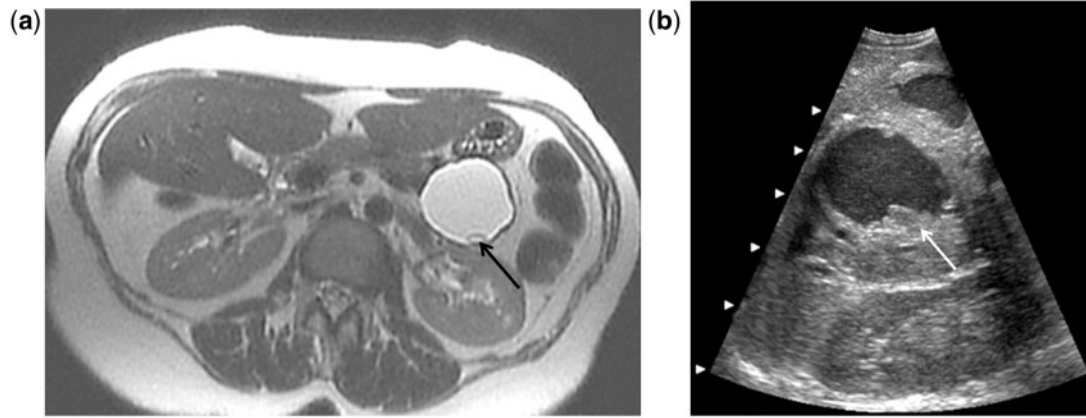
Cystic pancreatic incidentaloma found in a 50-year-old woman on an MR study performed to evaluate abnormal liver function tests. (a) T2-weighted axial MR image shows a 3.2 cm cystic lesion with a mural nodule (arrow) in the pancreatic tail. (b) EUS was performed and demonstrates multiple nodules (arrow) and debris within this mucinous adenocarcinoma. The patient underwent a distal pancreatectomy.
